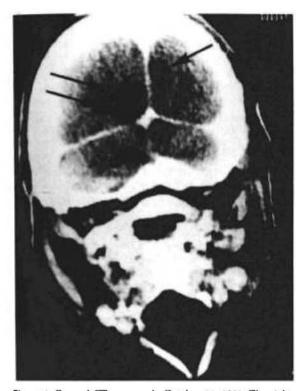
Coronal CT scan made October 14, 1981. The right upper calcarine infarction (single arrow) and the larger lower left calcarine infarction (double arrows), show the "checkerboard" anatomical correlate to the visual field defects.
